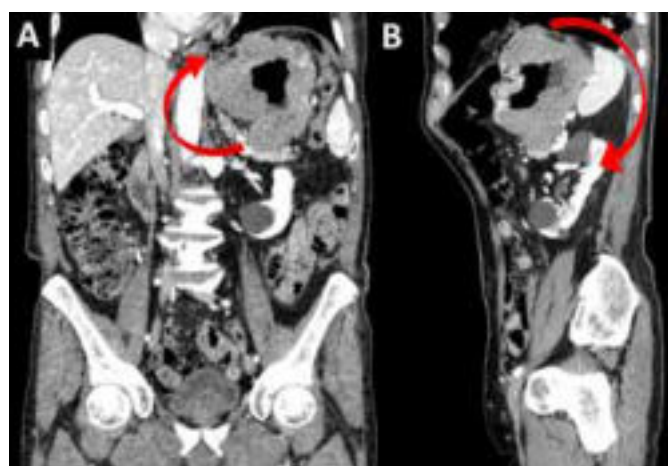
Abdominal Contrast-enhanced CT scan. A) Coronal multiplanar reformatted image: gastric tumor thickness of 4cm, infiltrating the left diaphragmatic dome and the ipsilateral crus (arrow), takes contact with the splenic hilum. B) Sagittal multiplanar reformatted image: the mass effect caused by the tumor, in epigastric and left hypochondriac region, determinating postero-lateral dislocation of the spleen and ptosis of the ipsilateral kidney (arrow).
